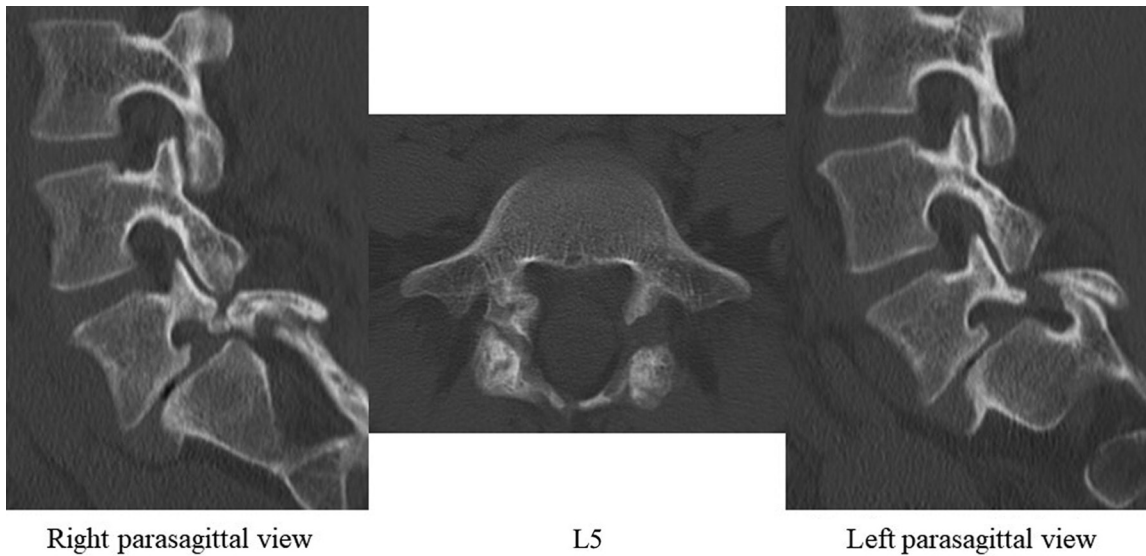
CT scans showing terminal-stage spondylolysis at L5 in the patient's mother. CT: computed tomography.
